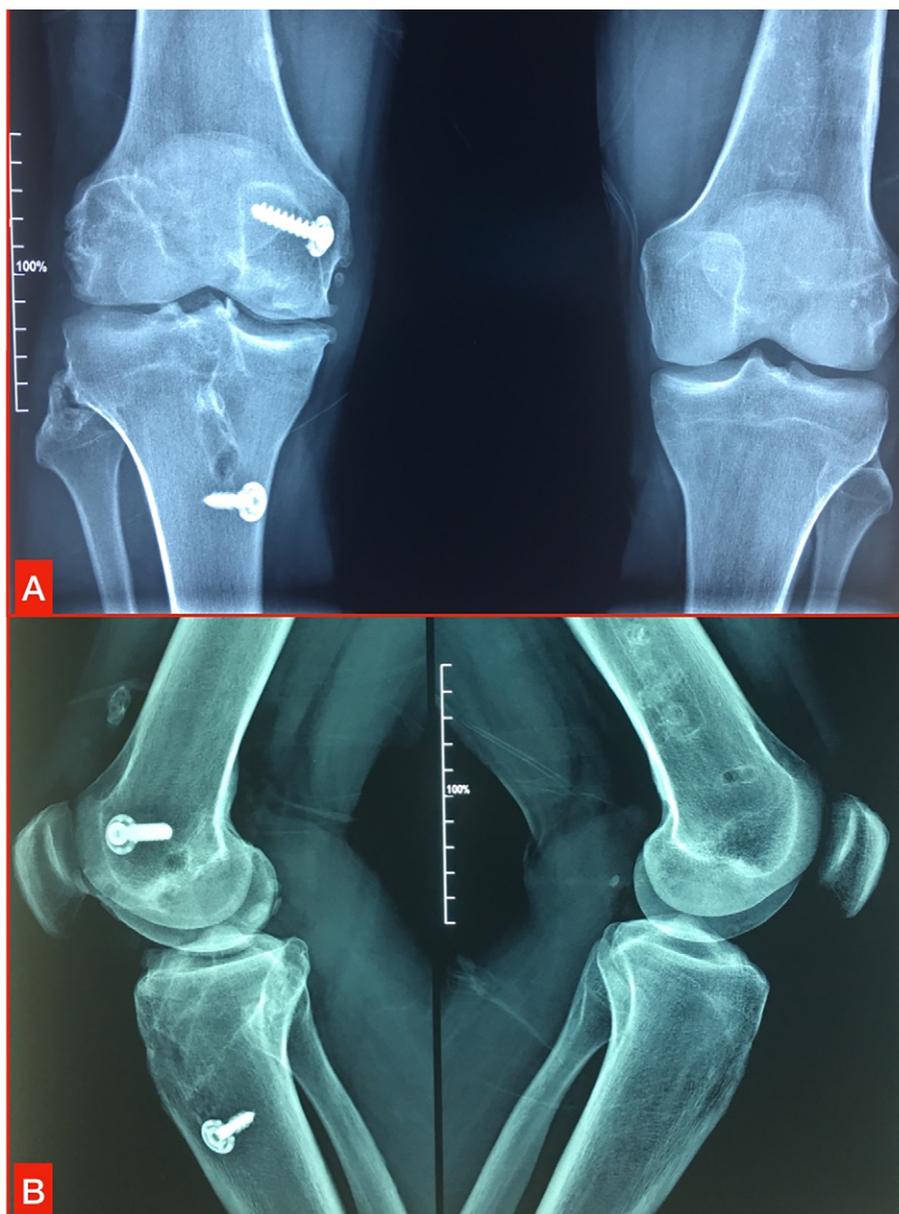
Bilateral anteroposterior (A) and lateral (B) knee X-ray of a 28-year-old male patient, 124 months postoperation. He initially sustained a KD III type of injury in his right knee.
